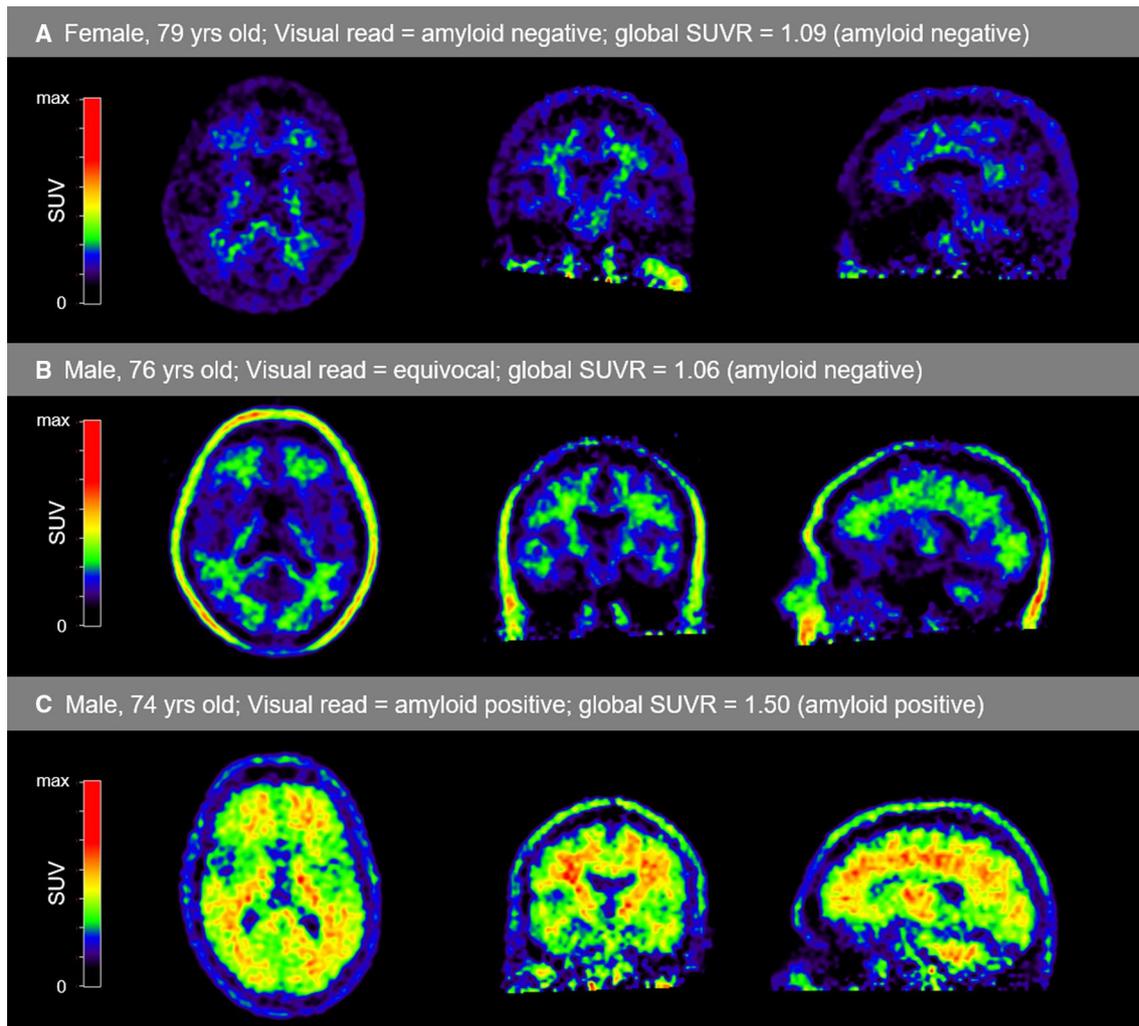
Representative images in axial (left), coronal (middle) and sagittal (right) view of [18F]florbetapir PET scans of patients with: A negative amyloid PET scan on both visual read and global SUVR quantification (< 1.10); B equivocal amyloid status on visual read but negative amyloid status on global SUVR quantification; C positive
